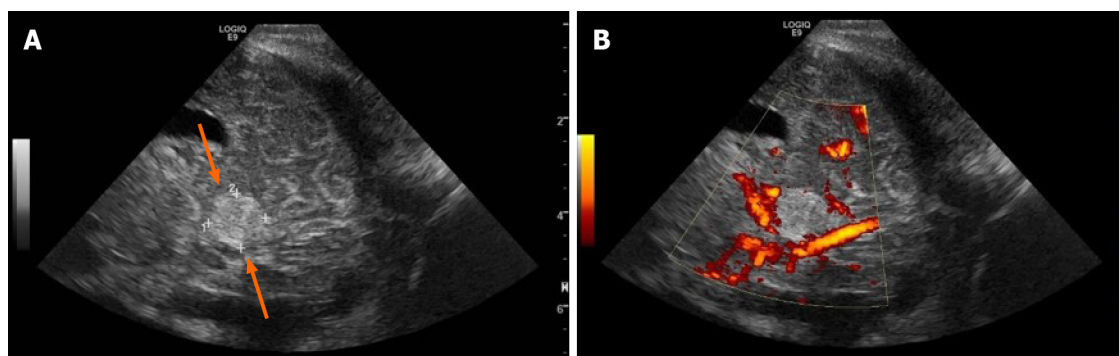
Head ultrasound through an oblique posterior parietal approach on 3rd day of life. The figure demonstrates an echogenic mass (arrows) in the posterior fossa, inferior to the tentorium, measuring 1.2 cm in its greatest dimension (A) with flow in the straight sinus and lack of flow on power Doppler within the mass (B).
